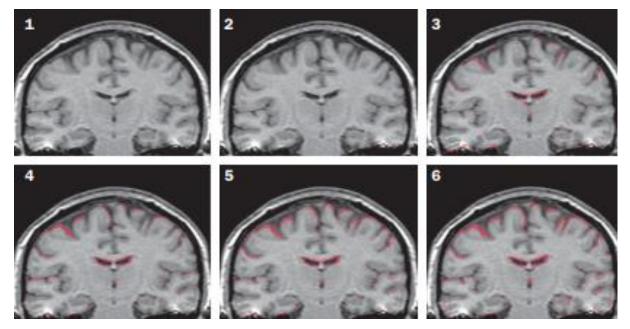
MRI scans from an initially nondemented patient developing AD. The scans have been acquired over a timespan of four years, with first dementia symptoms registered between scan 4 and 5. Note that the numbers do not correlate with the described six stages of AD (Fox & Schott, 2004).
